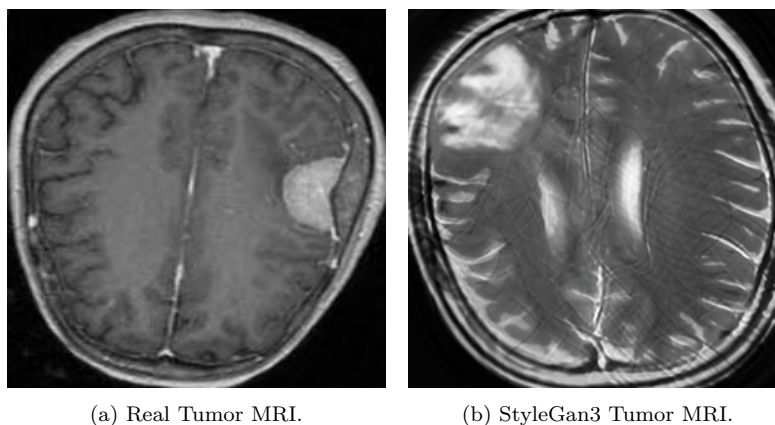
Real and Generated MRI
